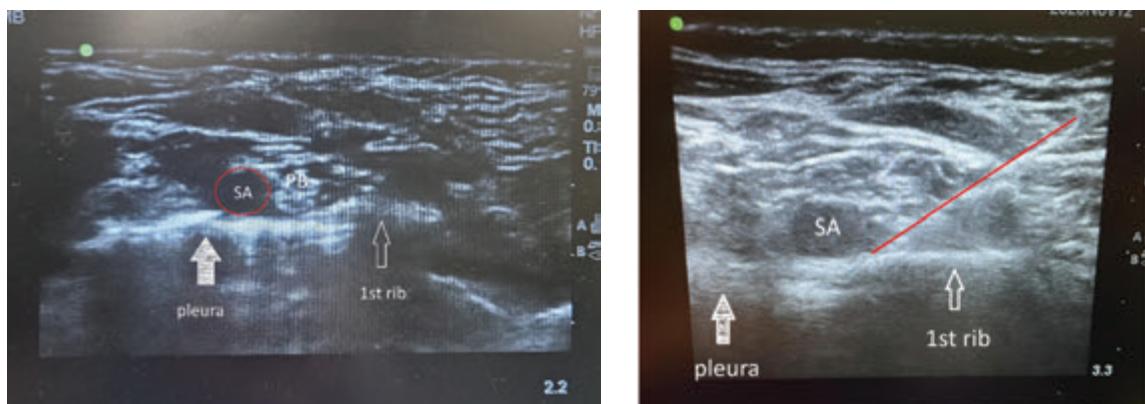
Ultrasound findings of supraclavicular brachial plexus block: pleura, first rib, SA- subclavian artery, and PB - brachial plexus posterolateral to the artery. The first image shows a US scan on a 2-year-old patient and the second an 11 year old patient. The red line is directed on the “corner pocket”
